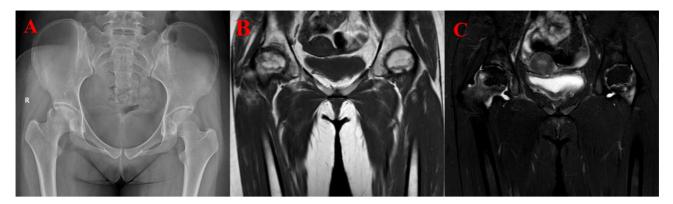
Representative case of a 14.8-year-old girl at the initial treatment who underwent two iv methylprednisolone pulse treatments due to SLE (cumulative dose 4.5 g), followed by continuous po prednisone (cumulative dose 11.625 g). After 1.17 years of continuous GC treatment (cumulative GC dose 17.475 g), the patient underwent imaging examinations due to bilateral hip pain and was diagnosed with bilateral SONFH. (A) X-ray radiograph shows an uneven density of the right femoral head. (B, C) Both femoral heads have a map-like change, mainly slightly low T1 and slightly high T2 signals, with low T1 and low T2 signals at the edges and slightly low T1 and slightly high T2 signals at the outer edges.
